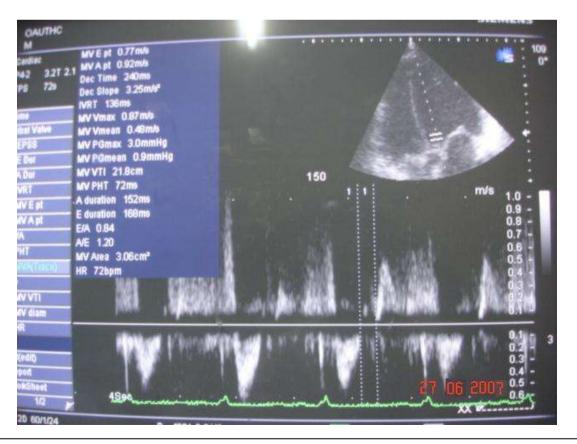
Doppler echocardiography showing prolonged isovolumic ventricular relaxation time in a study patient IVRT = 136ms
